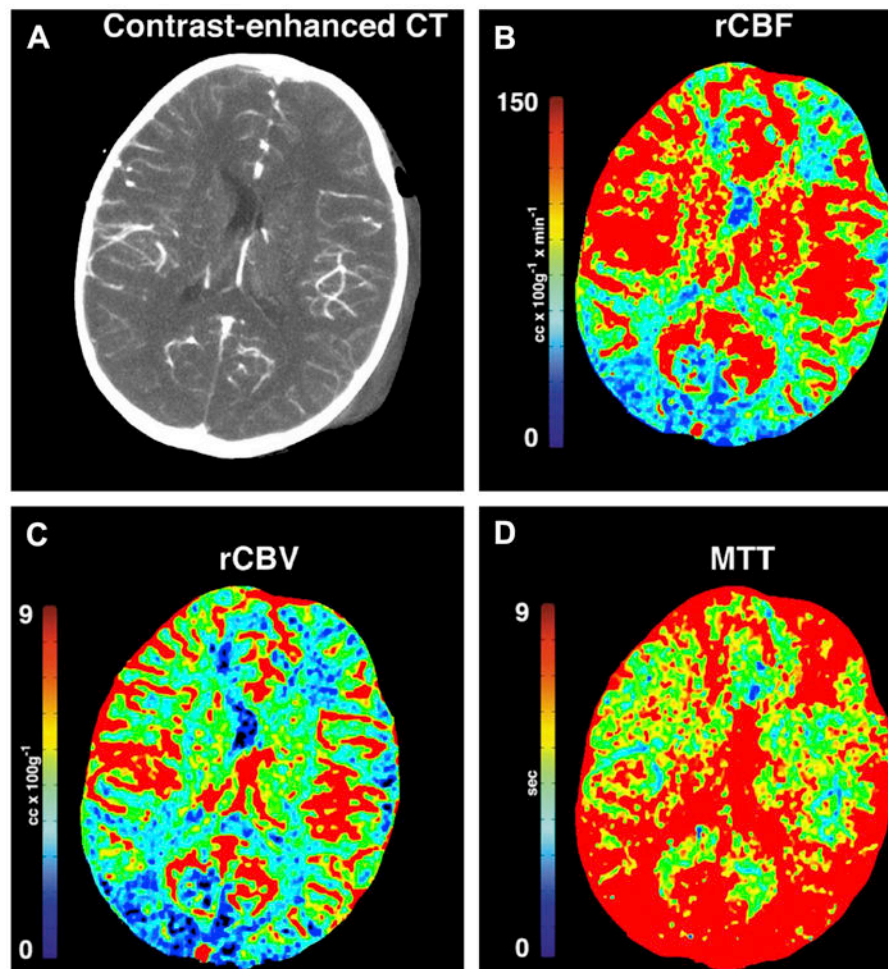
Contrast-enhanced and PCT images of a case of TBI with intracranial hypertension. The contrast enhanced CT (A) demonstrated left-sided scalp hematoma. The rCBF (B) and rCBV (C) trended toward lower values especially in the occipital lobes. The MTT (D) demonstrated significantly higher values, reflecting altered cerebral autoregulation after TBI.
